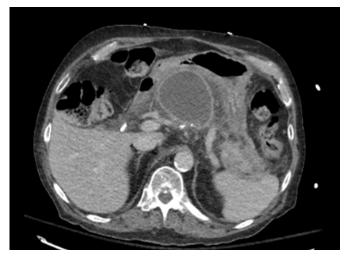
Axial CT showing walled-off fluid collection upon re-admission to hospital.
